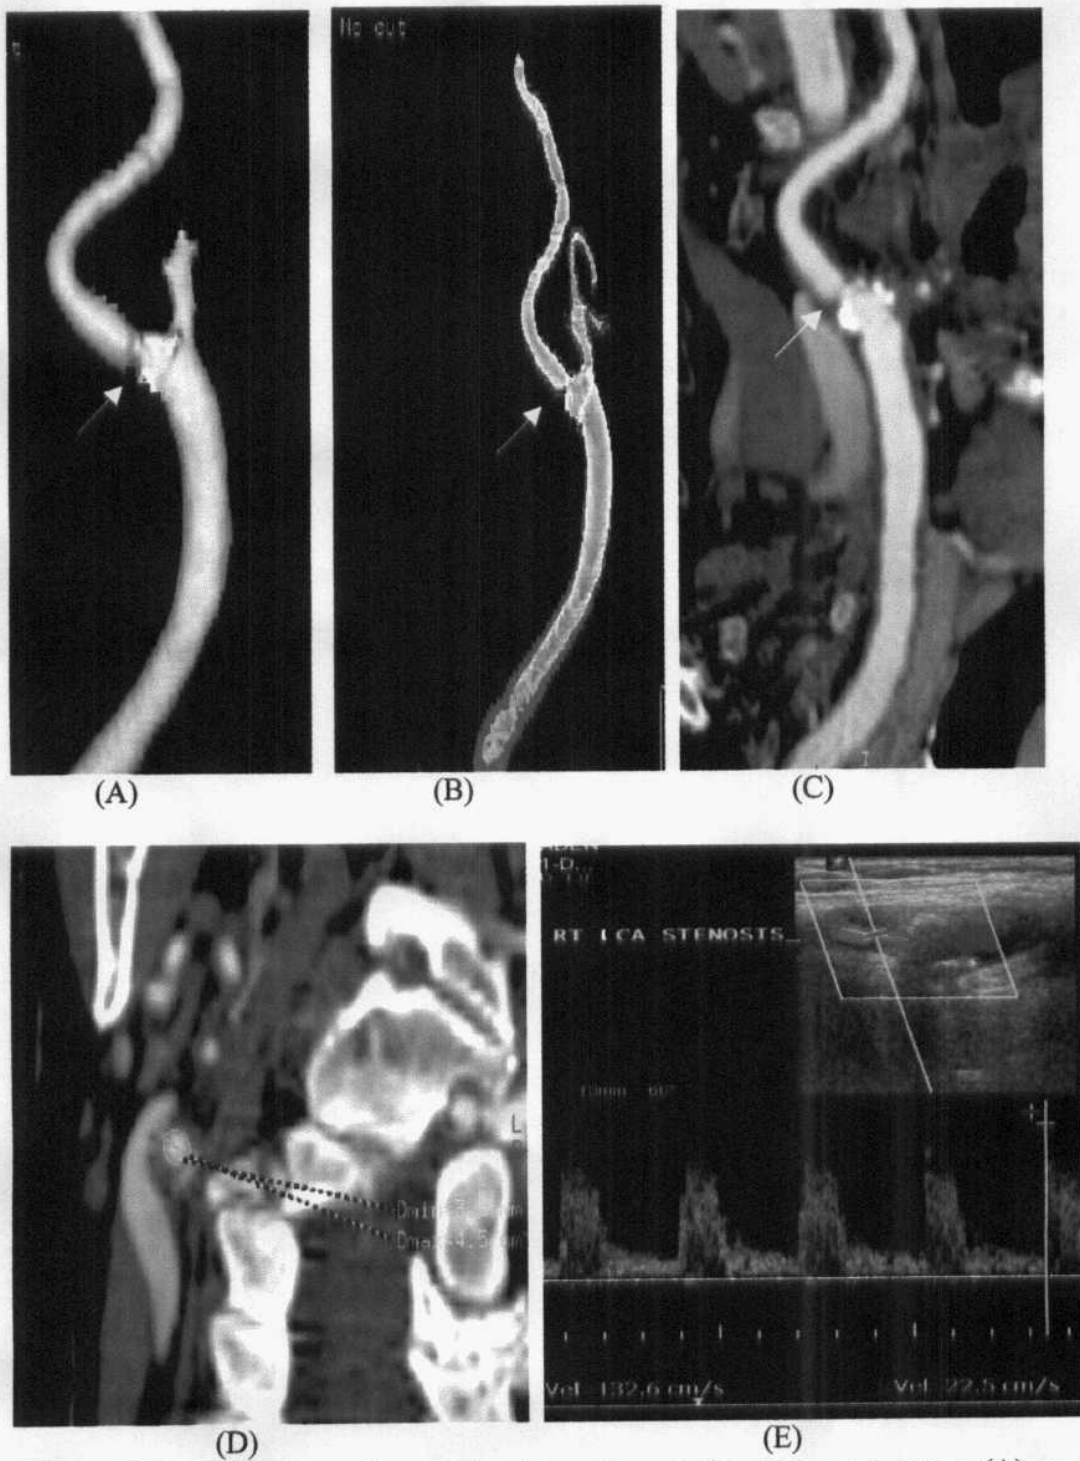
Right internal carotid artery stenosis by non transparent (A) and transparent (B) volume render techniques , curved reformat (C), axial reformat (D), and pulsed wave Doppler U/S (E).
